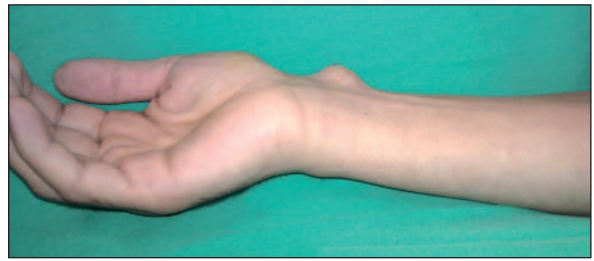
Image of right radial pseudoaneurysm. Pseudoaneurysm dimensions were 13.6x8 mm for the patent lumen with partially thrombosed sections on duplex ultrasonography.
